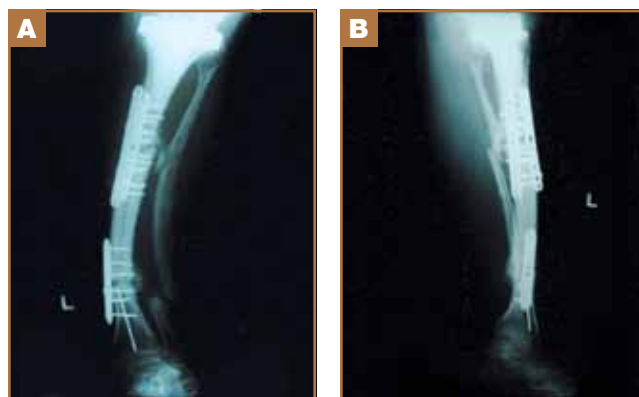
AP (A) and lateral (B) radiographs of left knee with tibia and osteotomy nonunion.
